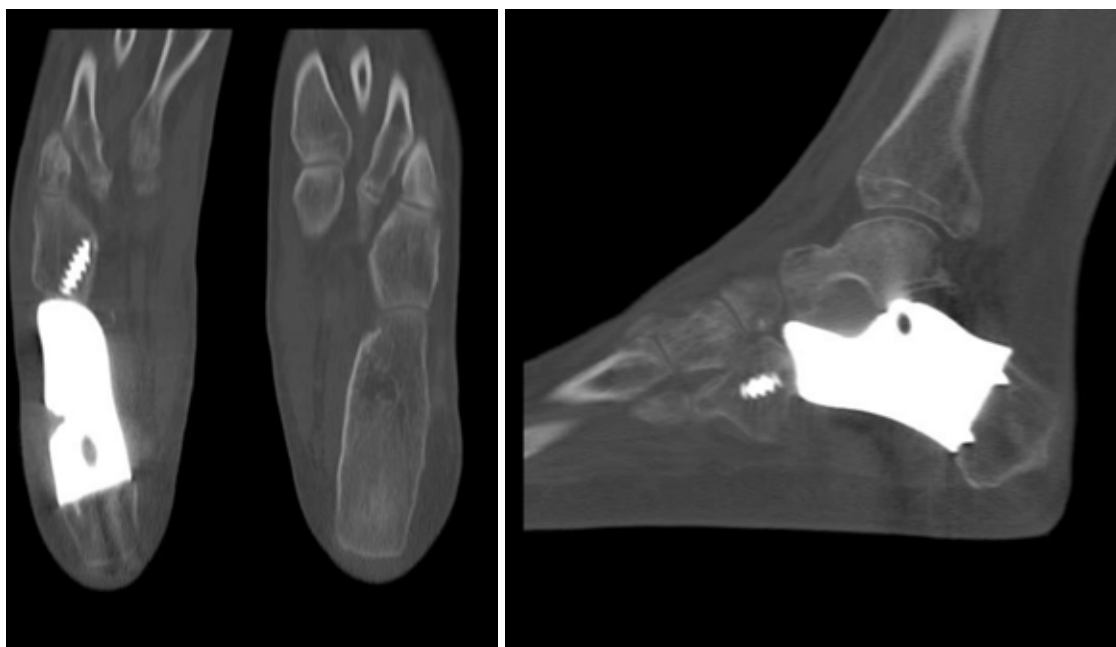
CT scan at 6 months showing a good positioning of the prosthesis and good integration with the remaining calcaneus.
